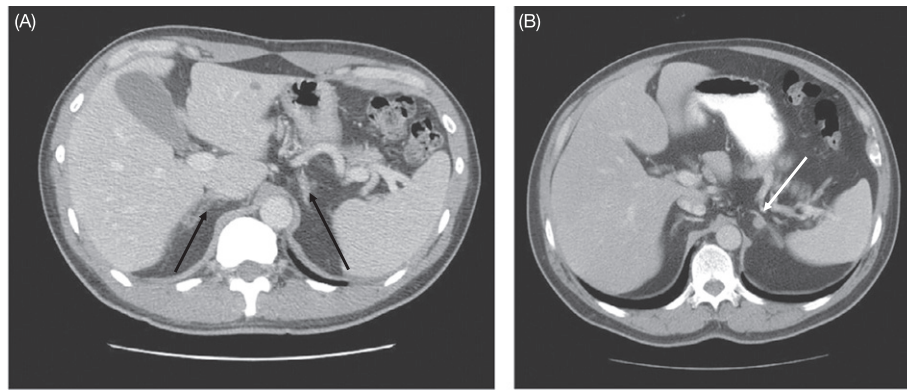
CT scan of adrenals demonstrating bilateral adrenal hyperplasia (A, black arrows) and a unilateral adrenal adenoma (B, white arrow).
